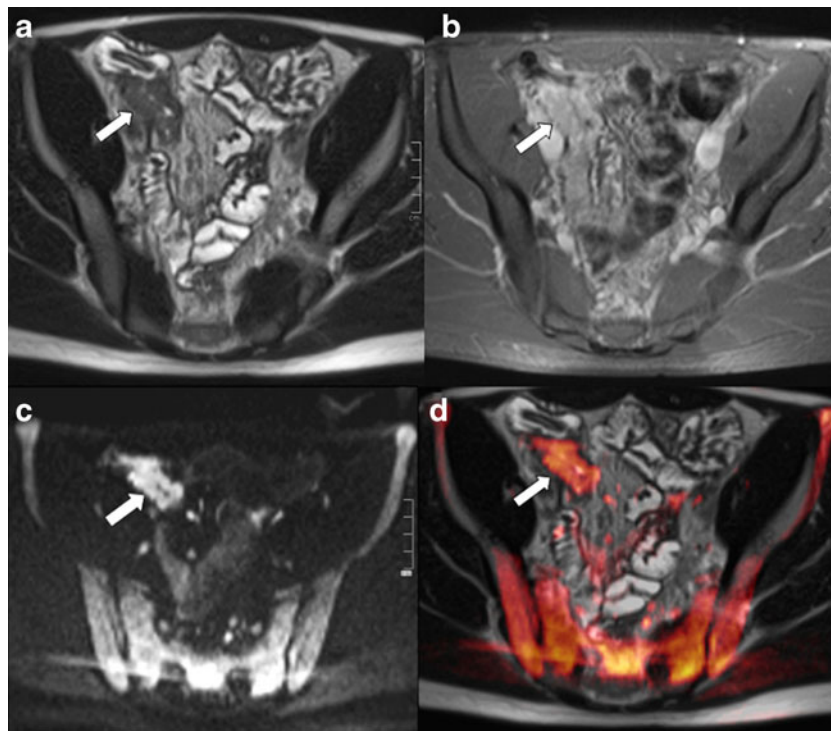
Segmental inflammatory wall lesion in the terminal ileum in a 20-year-old patient who had been diagnosed with Crohn disease 9 months previously and reported moderate clinical symptoms with abdominal pain and increased stool frequency at the time of examination. The lesion (arrows) is delineated on corresponding transverse cross-sections of T2-weighted HASTE (a), contrast-enhanced T1 2-D FLASH with fat saturation (b), b:800 DWI (c) acquisitions and on the fused image from
